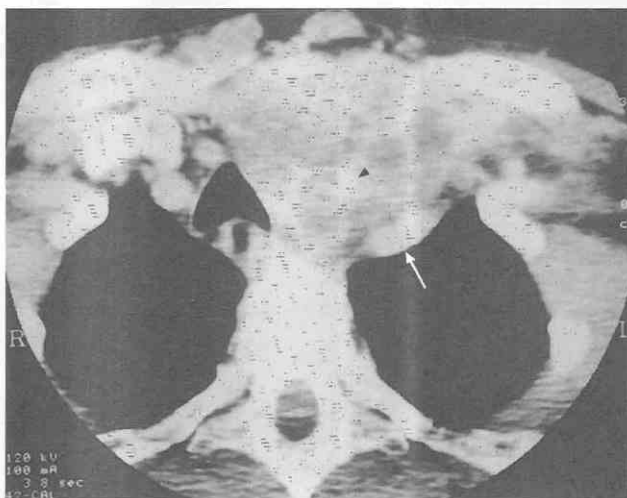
Anaplastic carcinoma. Axial postcontrast CT image demonstrates a lobulated, heterogeneously enhancing left thyroid lobe mass surrounding the left common carotid artery (arrowhead) and displacing the left subclavian artery (arrow) posteriorly. The mass extends into the upper mediastinum.
